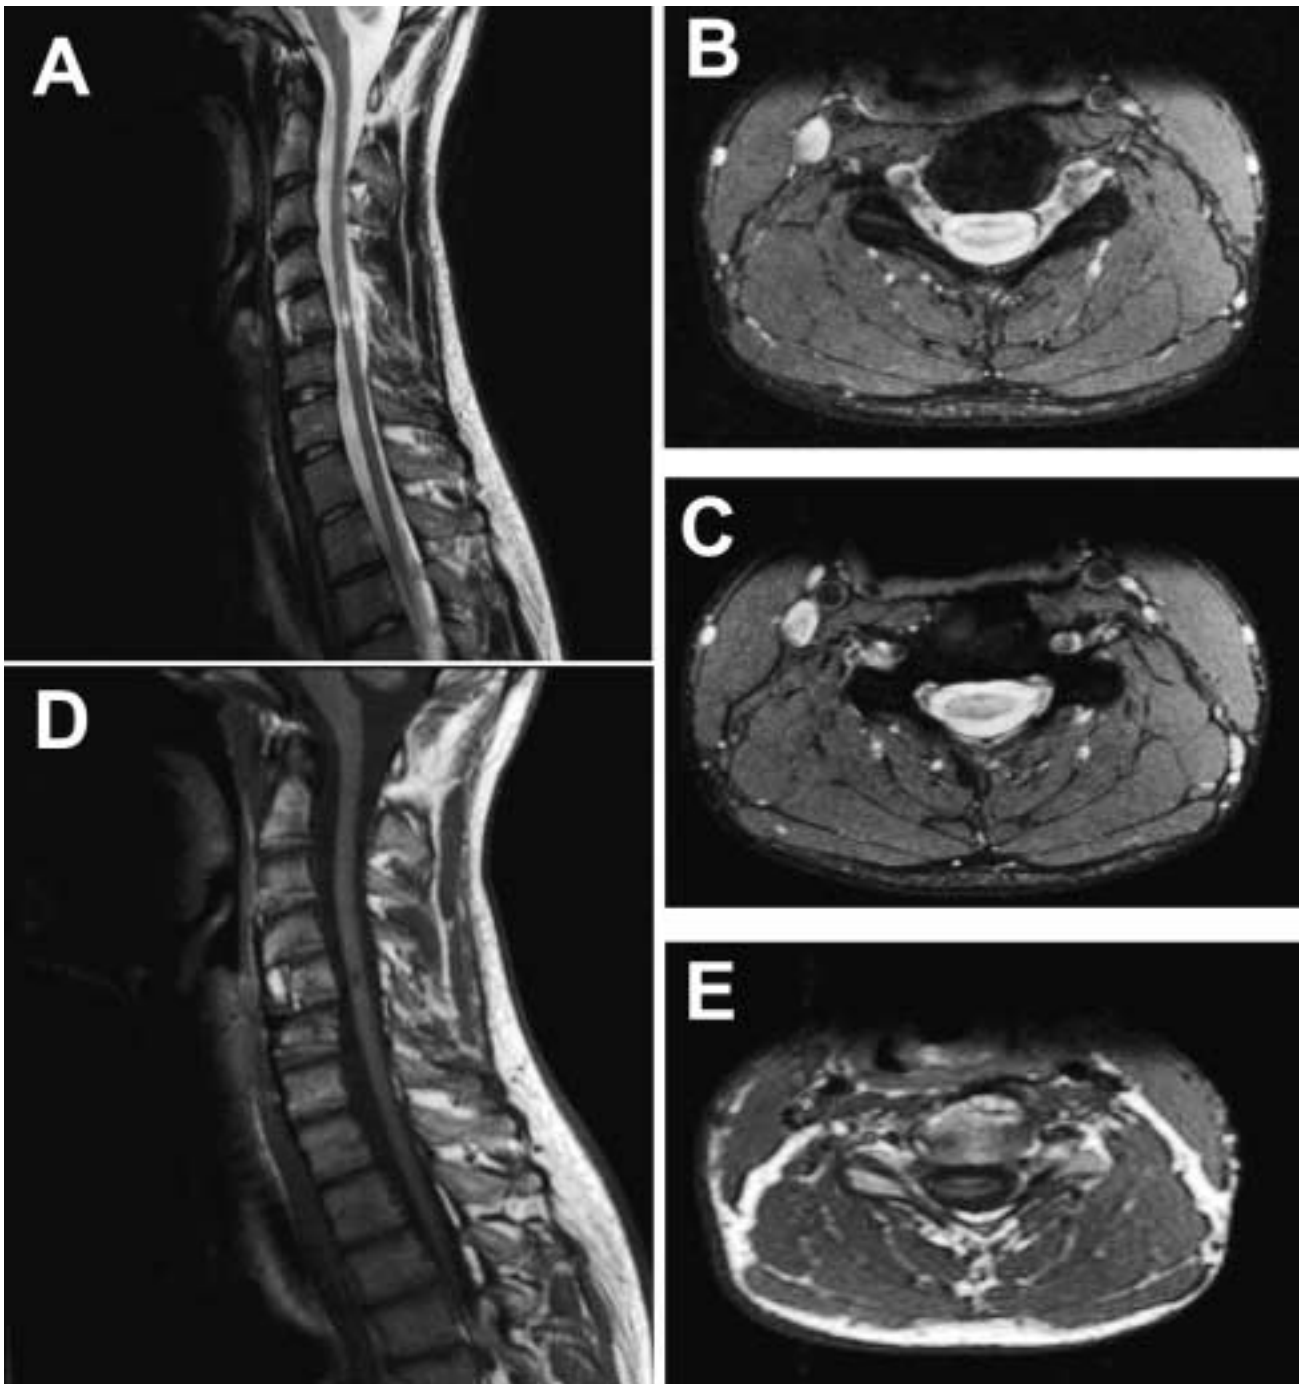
Magnetic resonance images show an incomplete spinal cord injury at C5/6 levels, 3 years after the accident, from a 20-year-old patient who jumped into unshallow water. A,D. Sagittal T2 (A) and T1-weighted (D) images. The region of hyperintense signal within the spinal cord of the T2-weighted image (light) indicates nonhemorrhagic spinal cord damage. B,C,E. Axial T2 and T1-weighted images of the spinal cord showing a more severe injury than in the sagittal plane. The authors estimated an anatomical injury of approximately 50%.
